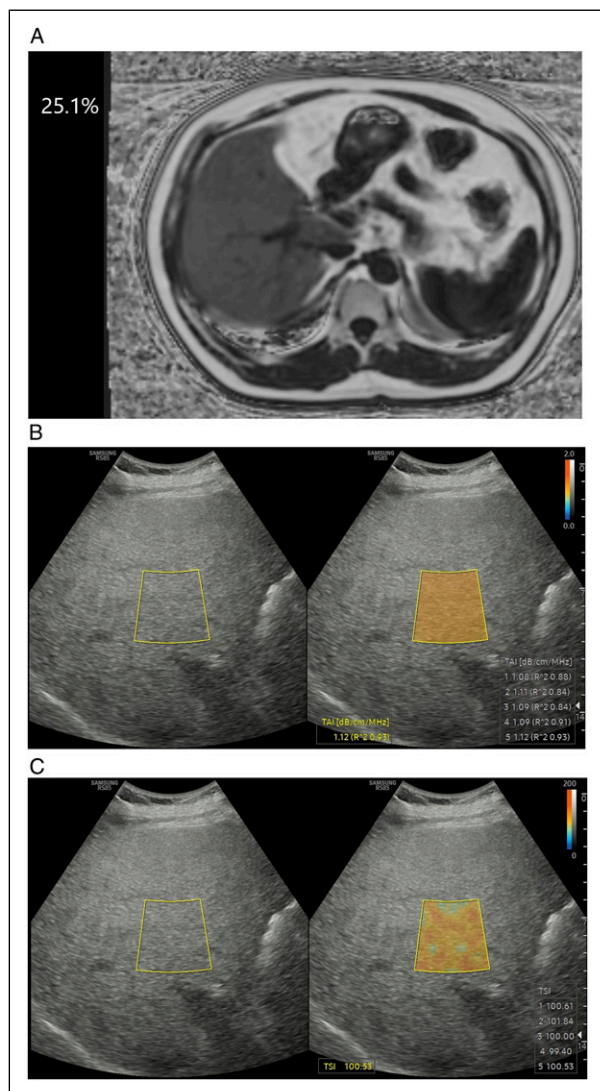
Magnetic resonance imaging proton density fat fraction (MRI PDFF) scan (A) of a 59 years old male patient revealed grade 3 steatosis with MRI PDFF value 25.1%. The patient underwent quantitative ultrasound imaging using Tissue attenuation imaging (TAI) (B) and Tissue scatter distribution imaging (TSI) (C) techniques. The median values of 5 measurements were 1.09 dB/cm/MHz and 100.53 for TAI and TSI techniques, respectively.
